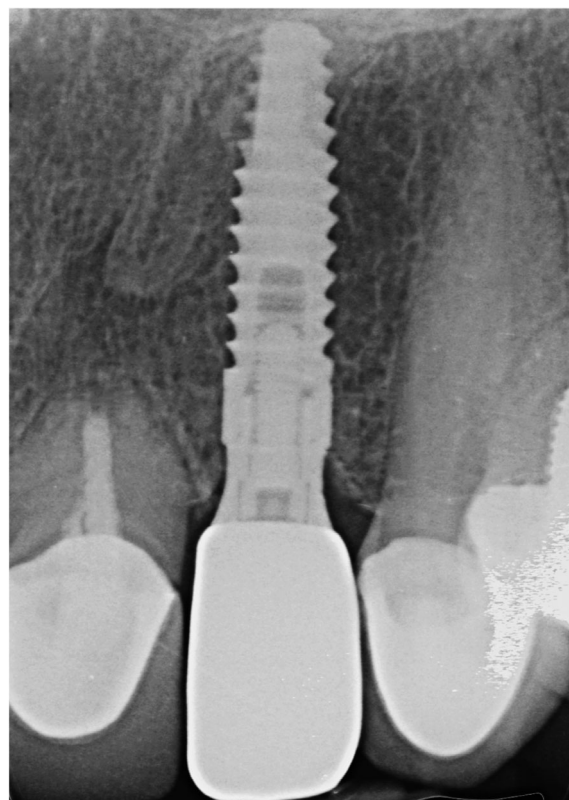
Radiograph of titanium base with restoration displaying space between the prosthesis and the bone
